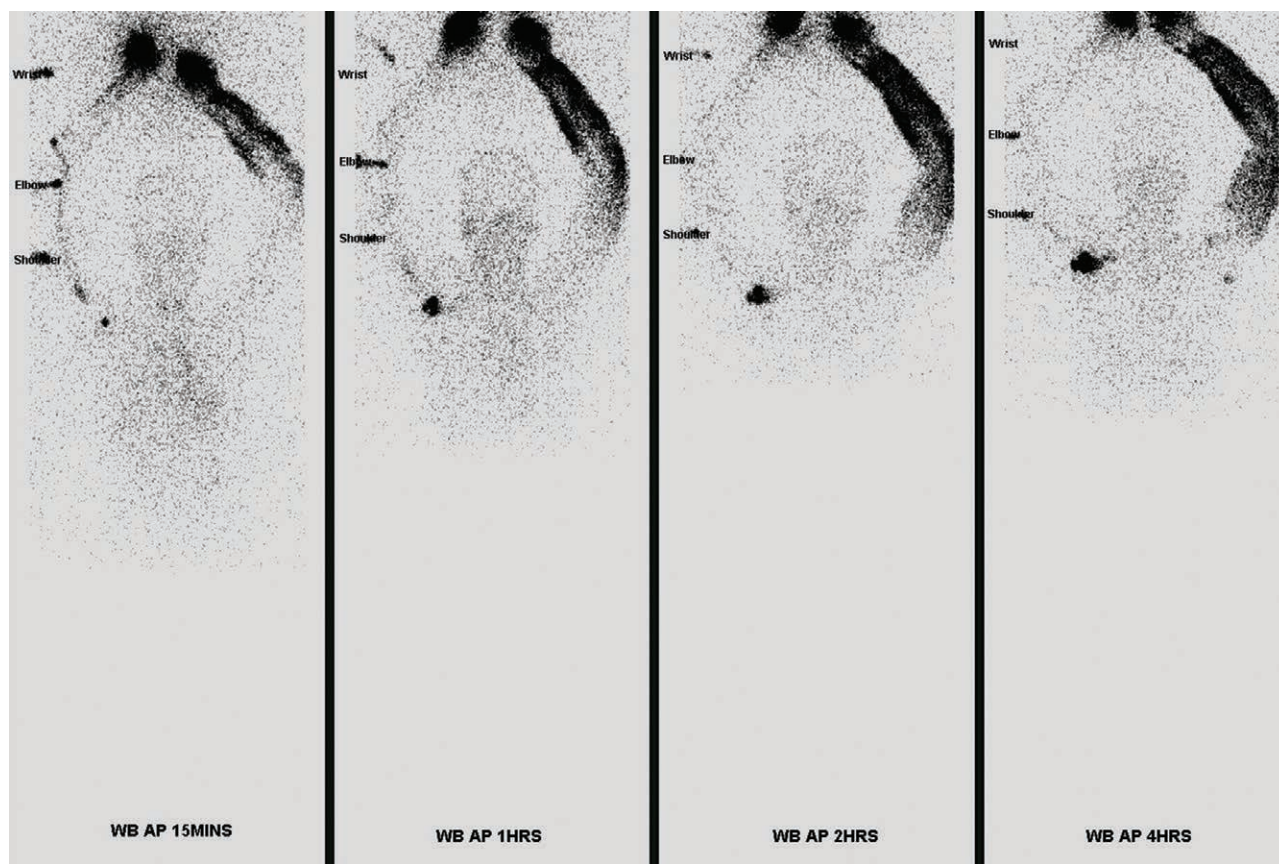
Preoperative lymphoscintigraphy. WB (whole body), AP (anteroposterior) view of upper limbs, 15 minutes, 1 hour, 2 hours, and 4 hours after injection, respectively.
